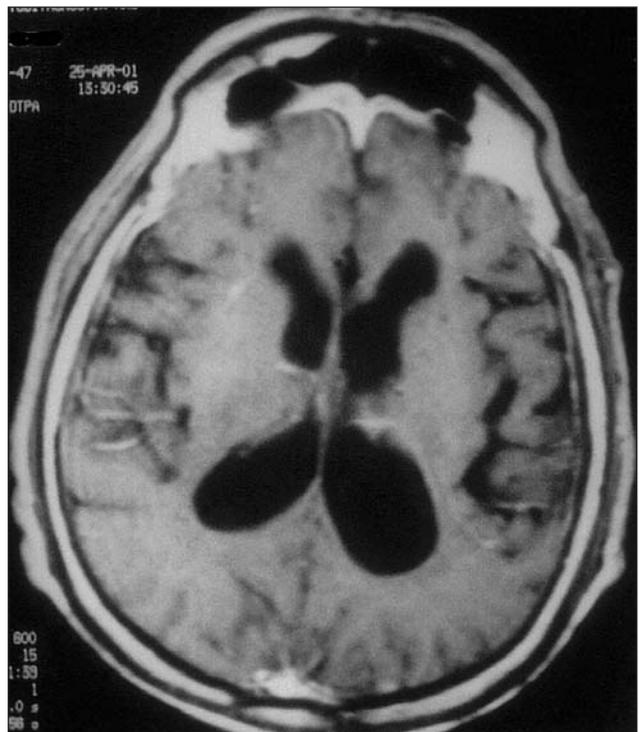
The postoperative axial MRI scan of the patient showing absence of the tumor.
